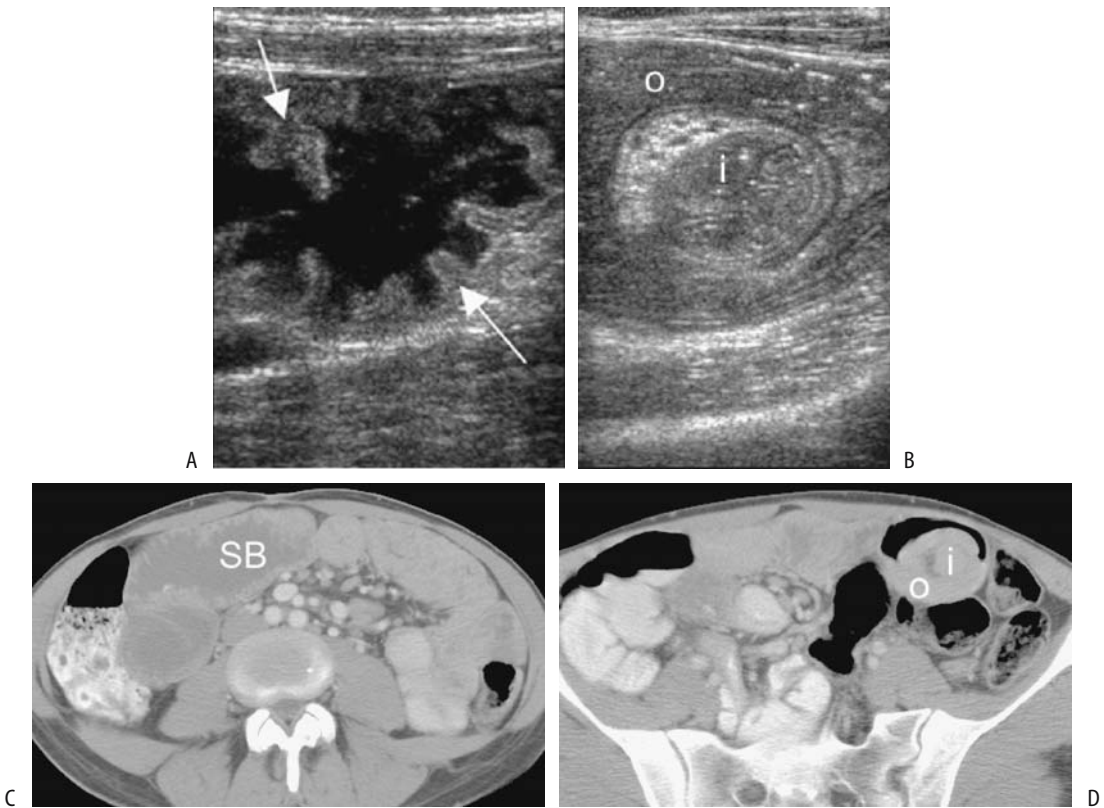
Celiac disease. A: Transverse sonogram in a 35-year-old woman reveals dilated, fluid-filled small bowel loops containing prominent folds (arrows). (b) An intussusception is evident in another US image. C,D: Transverse CT after oral and IV contrast also identified dilated fluid-filled small bowel loops (SB). D: An intussusception is evident in the left lower quadrant (i) (Courtesy of Martin E. O'Malley, M.D. Source: Wilson SR. Evaluation of the small intestine by ultrasonography. In: Gourtsoyannis NC, ed. Radiological Imaging of the Small Intestine. Heidelberg, Germany: Springer-Verlag, 2002 with permission.)
